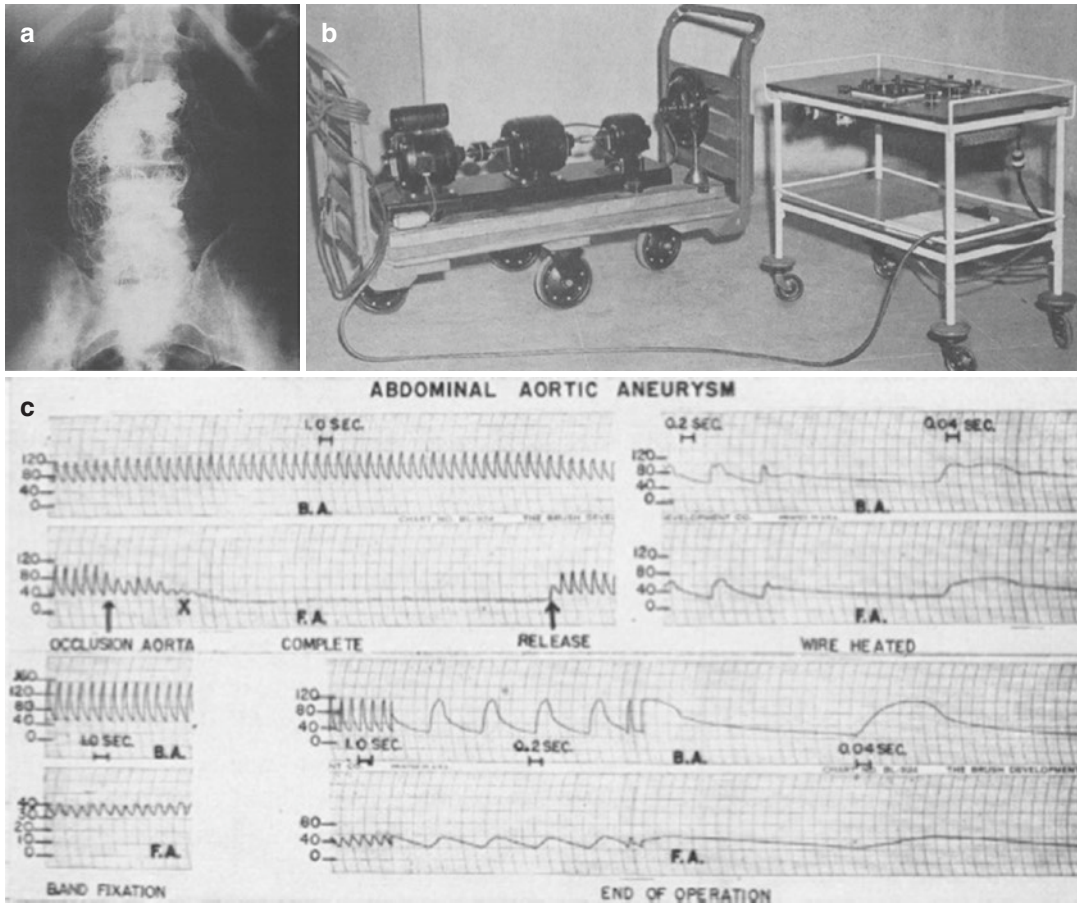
(a–c) Progressive constrictive occlusion of the aorta with wiring and electrothermic coagulation. (a) A roentgen ray of the abdomen taken after wiring and electrothermic coagulation of a very large arteriosclerotic aneurysm. The lesion has been stabilized now in excess of 8 years since operation. Note concentration of wire at the upper aortic-aneurysm junction for its impedance effect. (b) The electrical equipment employed in electrothermic coagulation of aneurysms. The equipment used to convert
